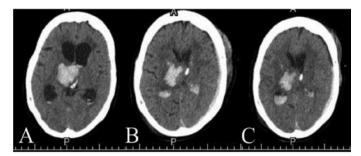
A shows the ictal CT scan of Patient D. B shows the post-rtPA scan with acute subdural hematoma at left frontoparietal convexity. C shows the end-of-treatment scan with the EVD clamped. The acute subdural hematoma remains relatively unchanged.
